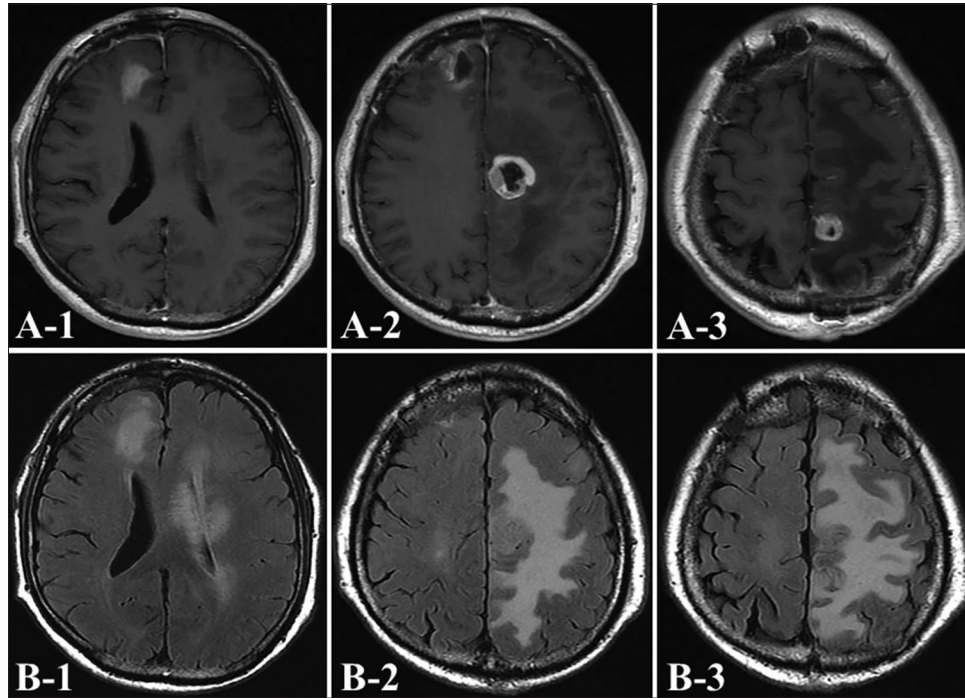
Images from postchemoradiotherapy axial gadolinium-enhanced T1-weighted imaging (a) and fluid-attenuated inversion recovery magnetic resonance imaging (b) demonstrating the residual tumors growing further, and the peritumoral edema is worse.
